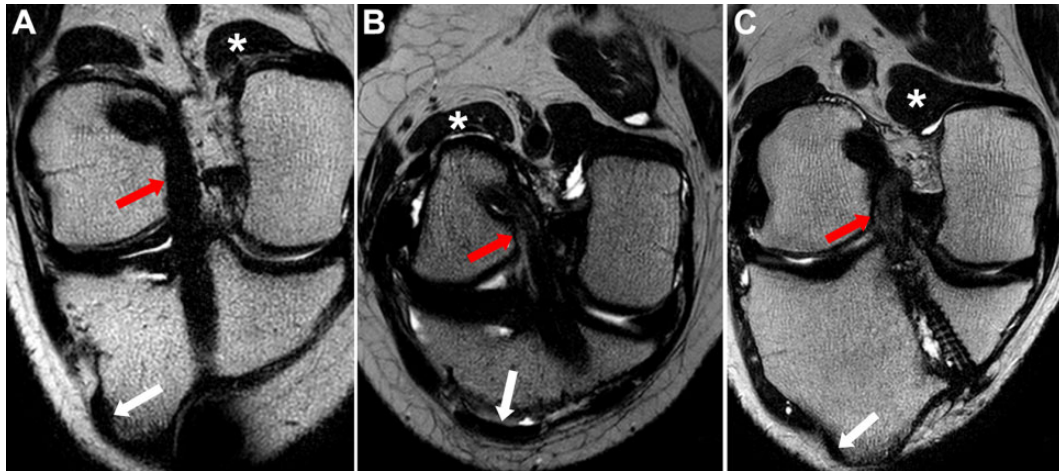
MRI scans after ACL reconstruction: oblique coronal view. White arrow, patellar tendon for low-signal MRI intensity; asterisk, gastrocnemius muscle for intermediate-signal MRI intensity; red arrow, ACL graft. ACL, anterior cruciate ligament; MRI, magnetic resonance imaging.
